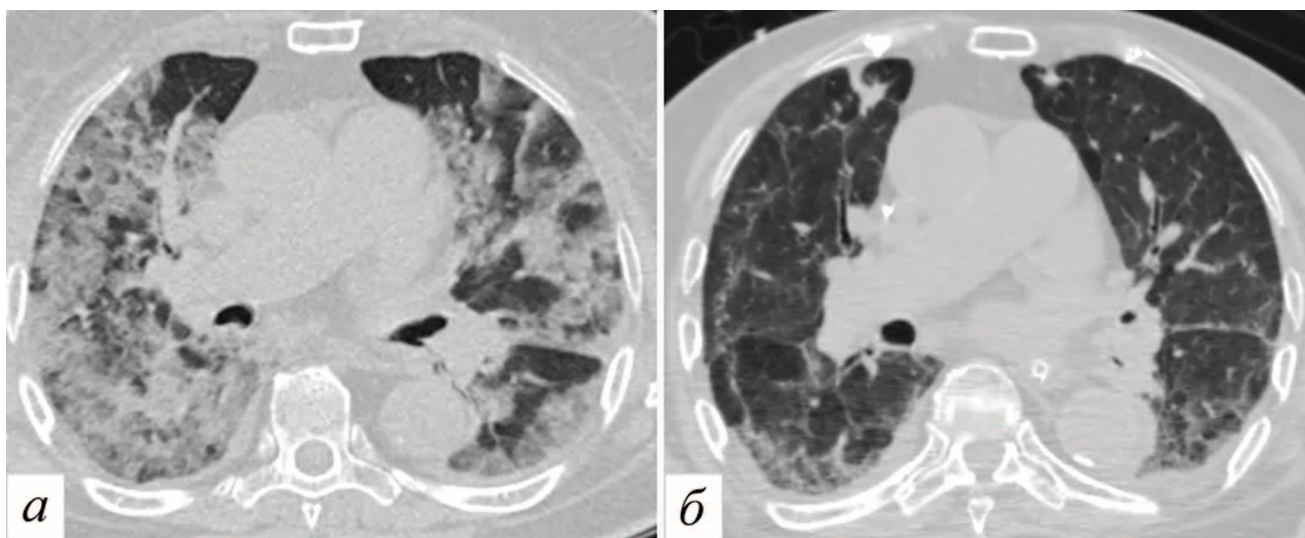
Patient A., 88 years old. COVID-19 (PCR+), one year after the acute phase of the disease. Thoracic CT scans in the axial projection, a — examination dated November 4, 2020, б — examination dated November 2, 2021. In place of extensive hardenings (consolidations, “ground glass”), there remain inhomogeneous areas of “ground glass” of low intensity with fuzzy contours, against which linear hardenings are presented, incl. in the form of characteristic arcs. Bronchiectasia and other areas of deformity are not clearly visible, and changes may correspond to OP or a pattern of nonspecific interstitial pneumonia
